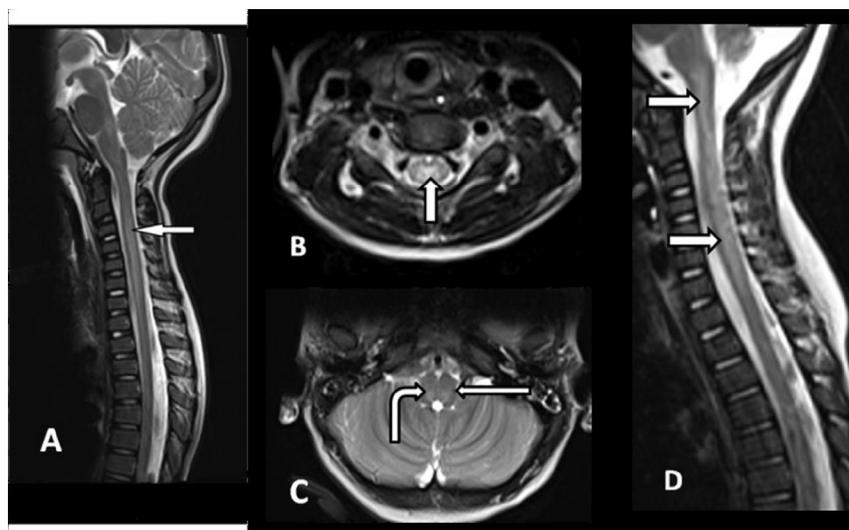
Typical Magnetic Resonance Imaging (MRI) abnormality in AFM due to EV D68.¹ The Saggital T2 weighted sequences (A&D) showing longitudinal hyper-intense signal and the Axial T2-Weighted sequences (B&C) showing hyper-intensity in spinal cord Grey matter(B) and dorsal brainstem(C).
